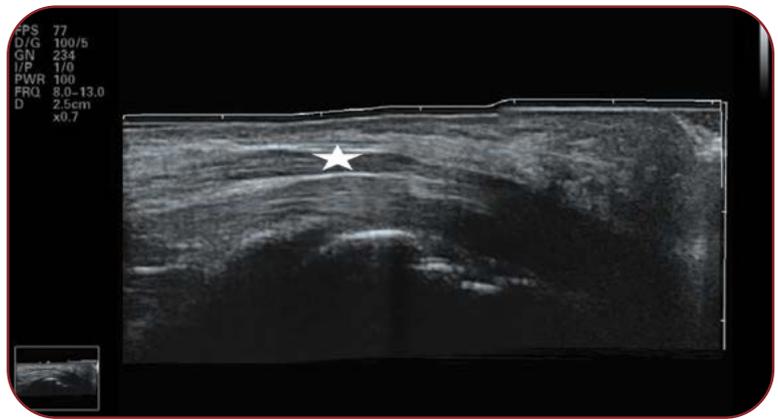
Ultrasound image of the median nerve in B mode using a linear array at the carpal tunnel level; the star marking represents the median nerve longitudinal view
